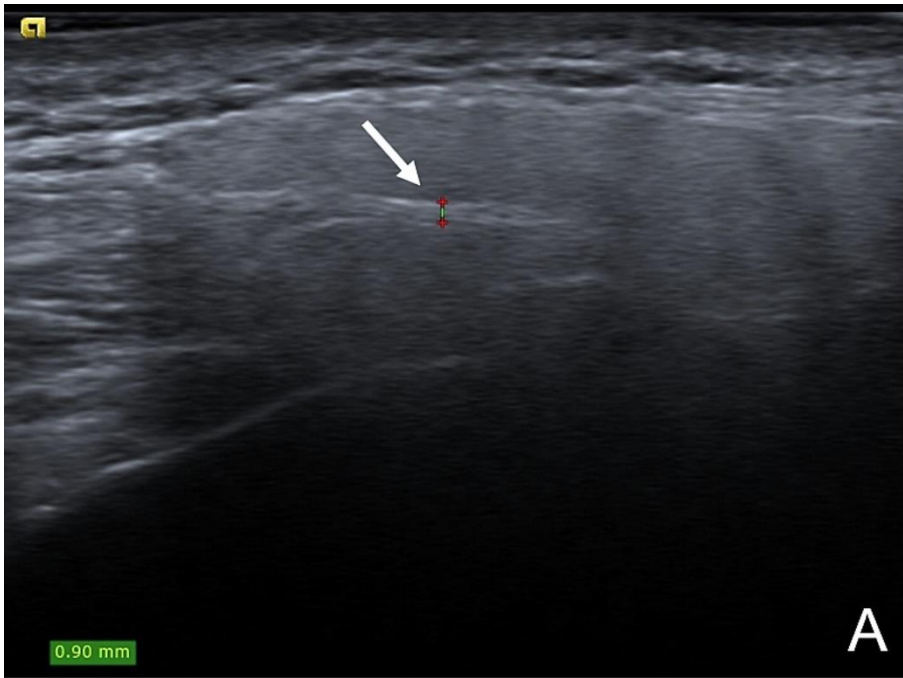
Facial Nerve Ultrasound at T1 in a representative patient: A. Affected side, B. Control side.
